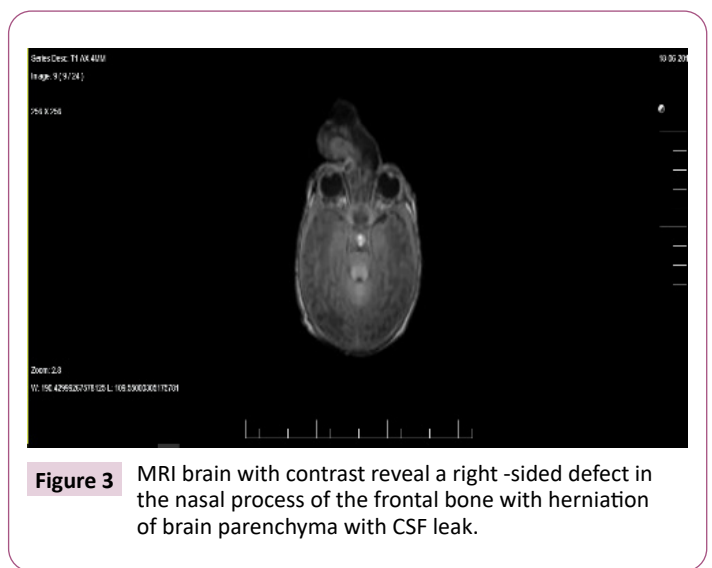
MRI brain with contrast reveal a right -sided defect in the nasal process of the frontal bone with herniation of brain parenchyma with CSF leak.
